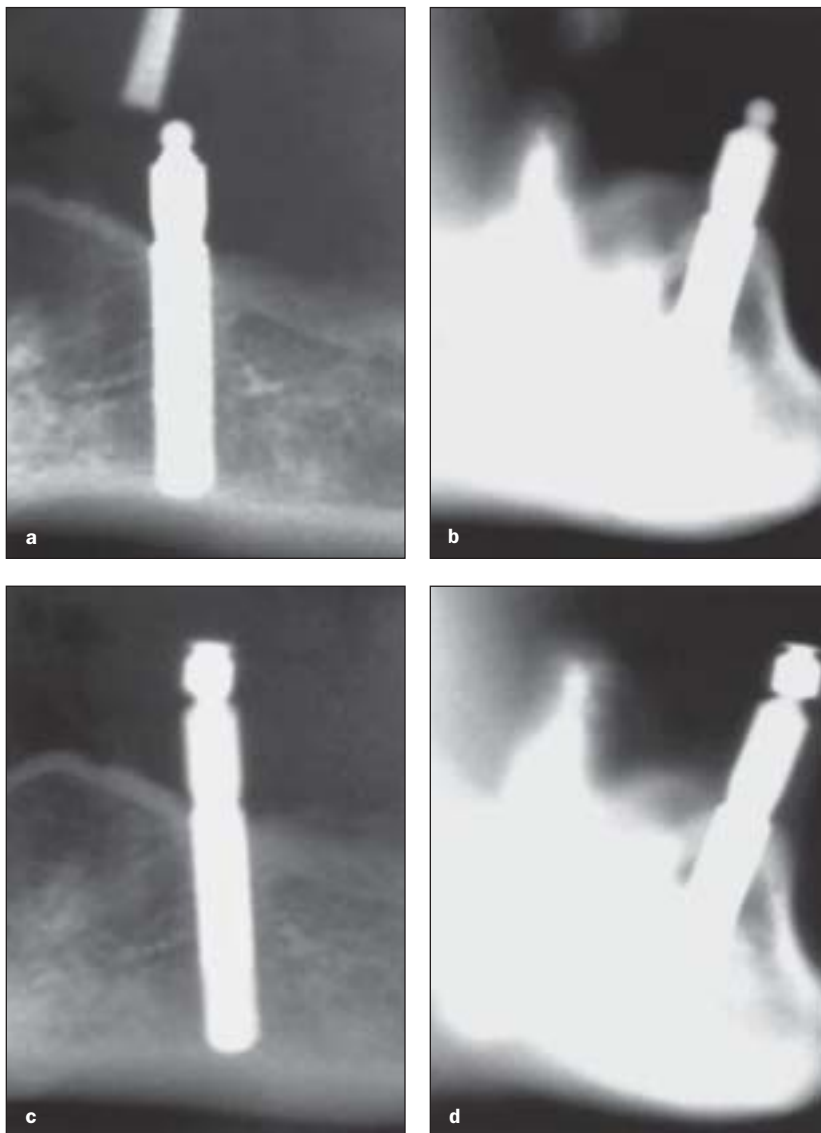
Serial radiographic evaluation of interproximal bone levels at microthreaded implants. (a) Mesiodistal image of implant at abutment placement reveals the crest of bone at both the mesial and distal aspects of the implant reference point. (b) Buccolingual image of the implant at abutment placement reveals buccal and lingual crestal bone approximating the implant reference point. (c) Mesiodistal image of implant at 60-month follow-up reveals the crest of bone at both the mesial and distal aspects of the implant reference point. (d) Buccolingual image of the implant at 60-month follow-up reveals buccal and lingual crestal bone approximating the implant reference point.
